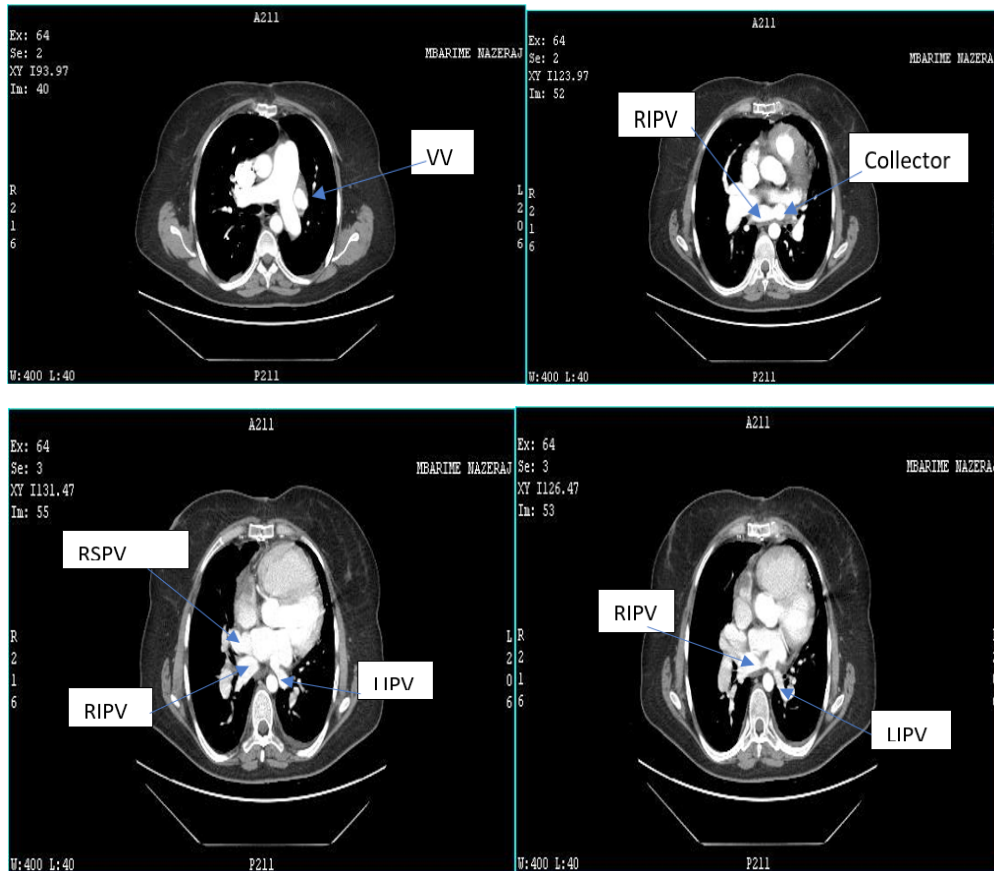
Photo of postoperative computed tomography. VV-vertical vein,RIPV-right inferior pulmonary vein,RSPV-right superior pulmonary vein,LIPV-left inferior pulmonary vein. Post operative echocardiography showed no residual shunt, trivial tricuspid regurgitation and pulmonary pressure about 30 mmHg. The patient is discharged in good health condition.
